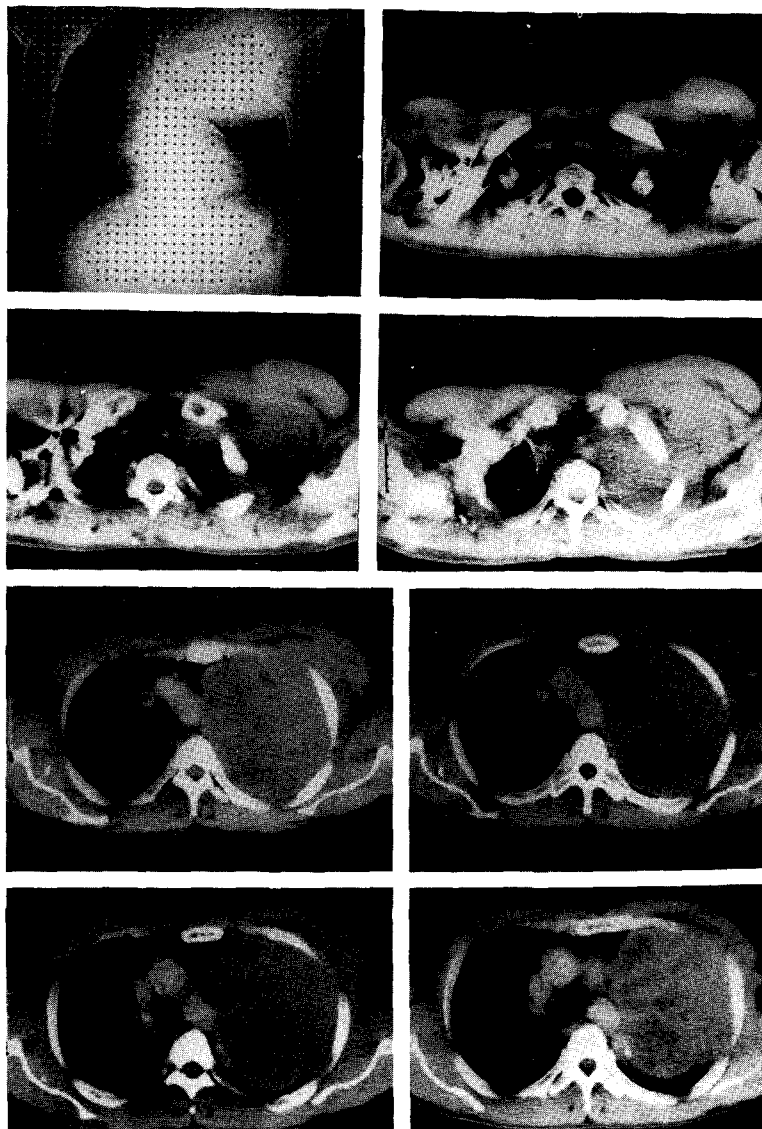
Chest CT shows large inhomogenous mass in LUL with direct invasion into adjacent rib and chest wall. There are noted bulging of left upper chest wall and mild shifting of mediastinal into right side. It is no significant evidence of lymphadenopathy.
